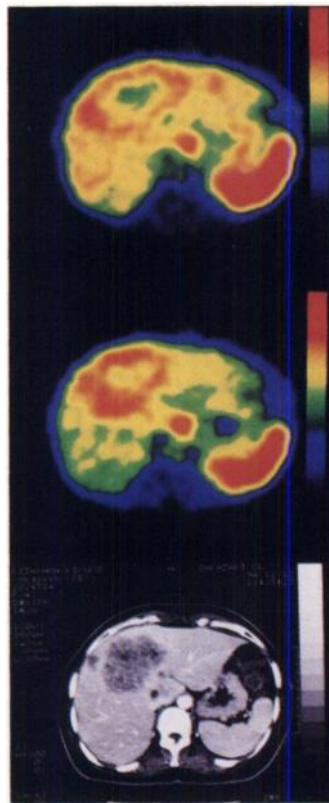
A 46-yr-old woman with hepatic metastasis from colon cancer. Top, middle and bottom images are PET images during normotensive and hypertensive states and a CT scan, respectively. Compared to the normotensive state, the metastatic lesion shows increased flow relative to liver parenchyma in the hypertensive state.
